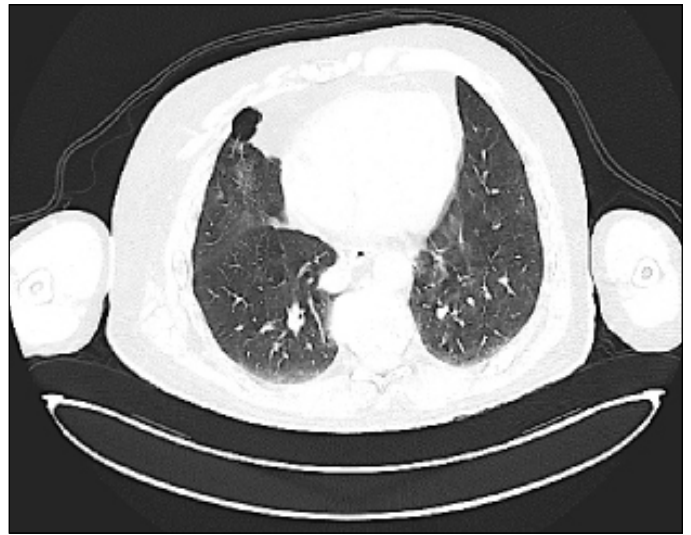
Chest CT scan: 18-mm paramediastinal pulmonary nodule in the right lower lobe (RLL).
